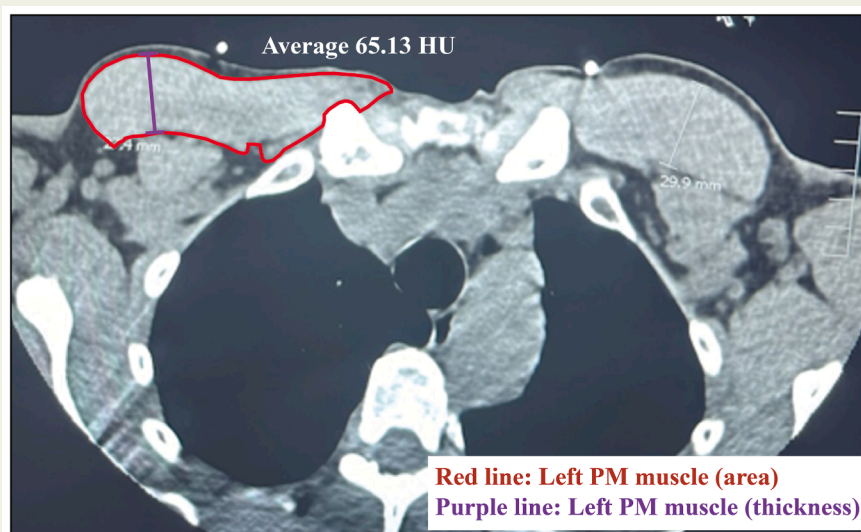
Representative CT scan image of PM muscle. The PM muscle is indicated (red line). PM area (red line = 2,184 mm²), thickness (purple line =27.4 mm) and density (65.13 HU) were calculated for each patient chest CT scan. The numbers above relate to the representative image provided.
